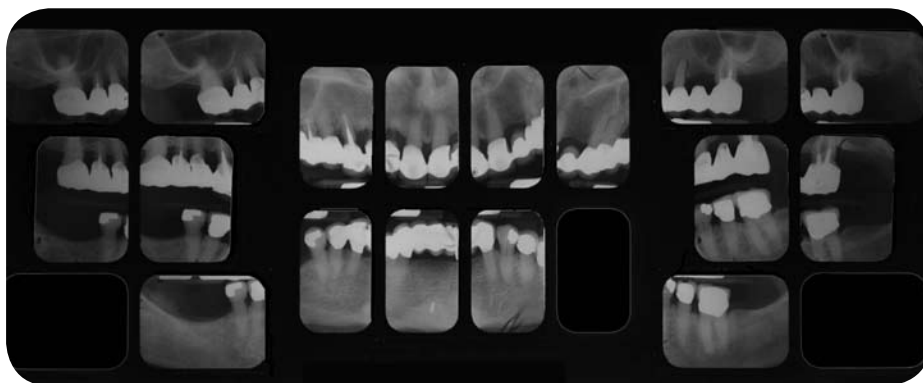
Radiographs of maxillary reconstruction with cross-arch stabilization at 20 years.
